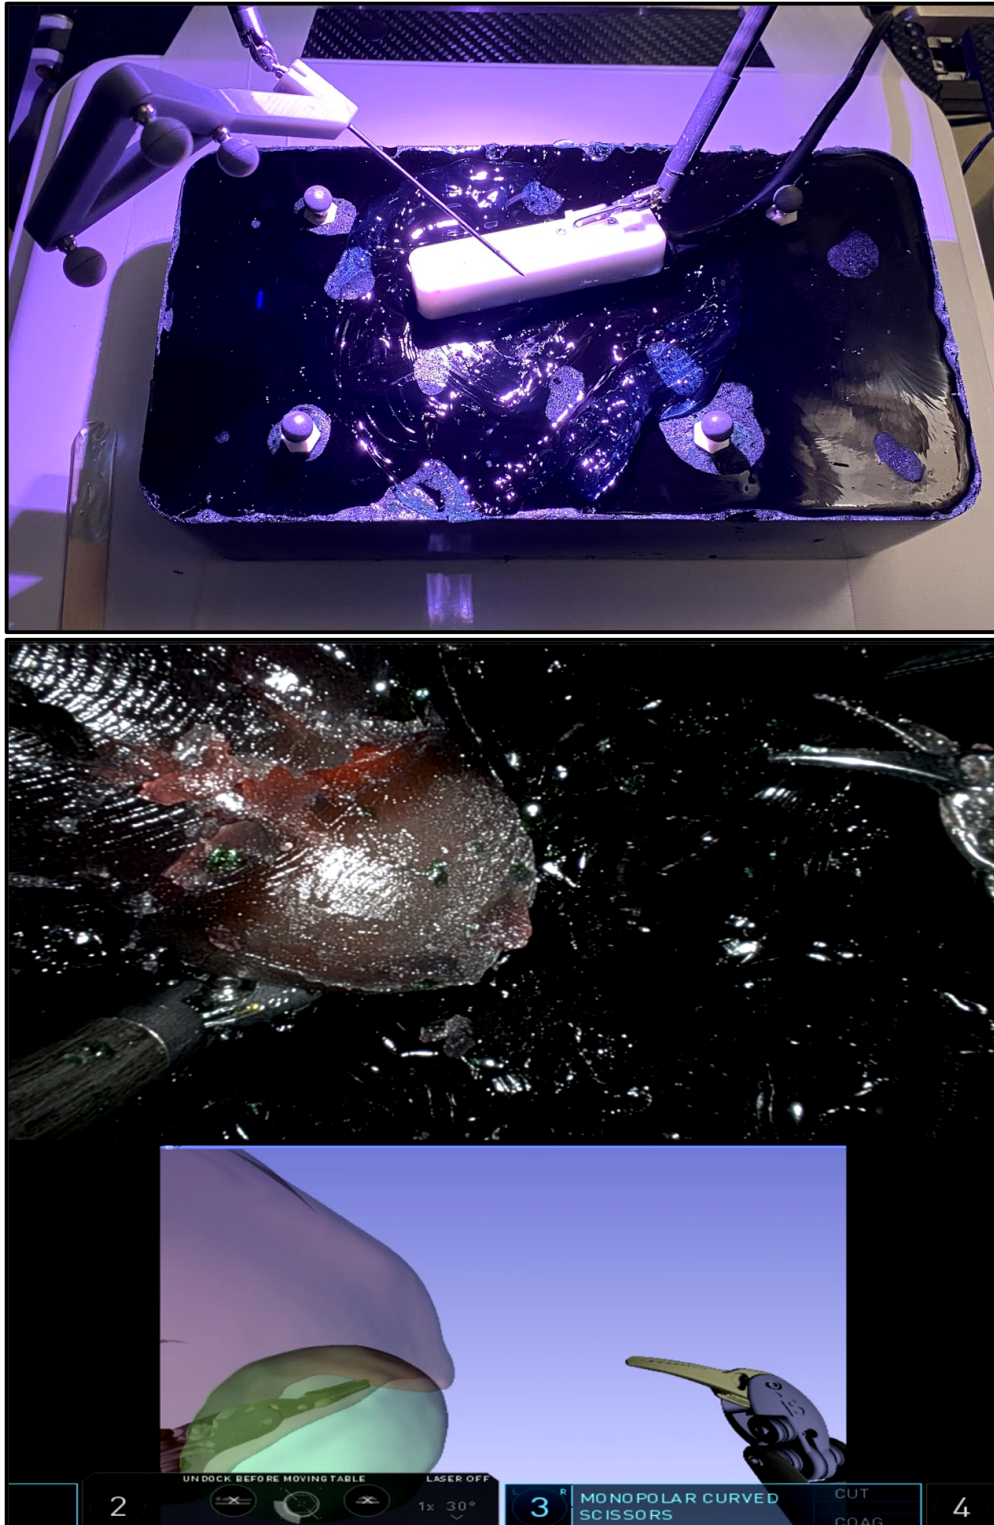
Experimental setup to evaluate clinical efficacy of ultrasound-based image guidance. (top) External view of needle placement activity using drop-in ultrasound. (bottom) Surgeon console view of tumor resection using image guidance.
